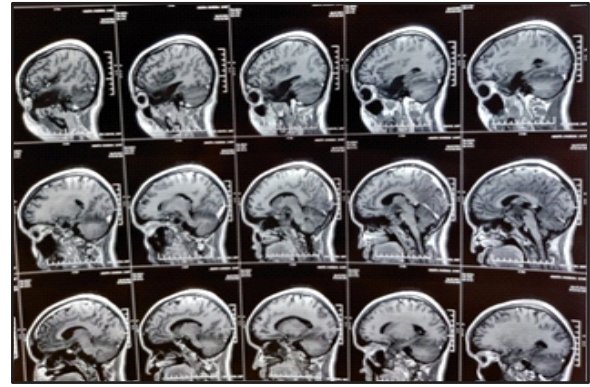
MRI brain showing residual para-sellar mass post chemotherapy
